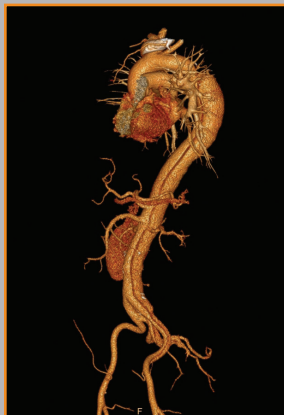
CTA with 3-D reconstruction of the aorta. This image shows the dissection extending from the descending thoracic aorta to the iliac arteries. The entry tear is in the proximal descending thoracic aorta.
